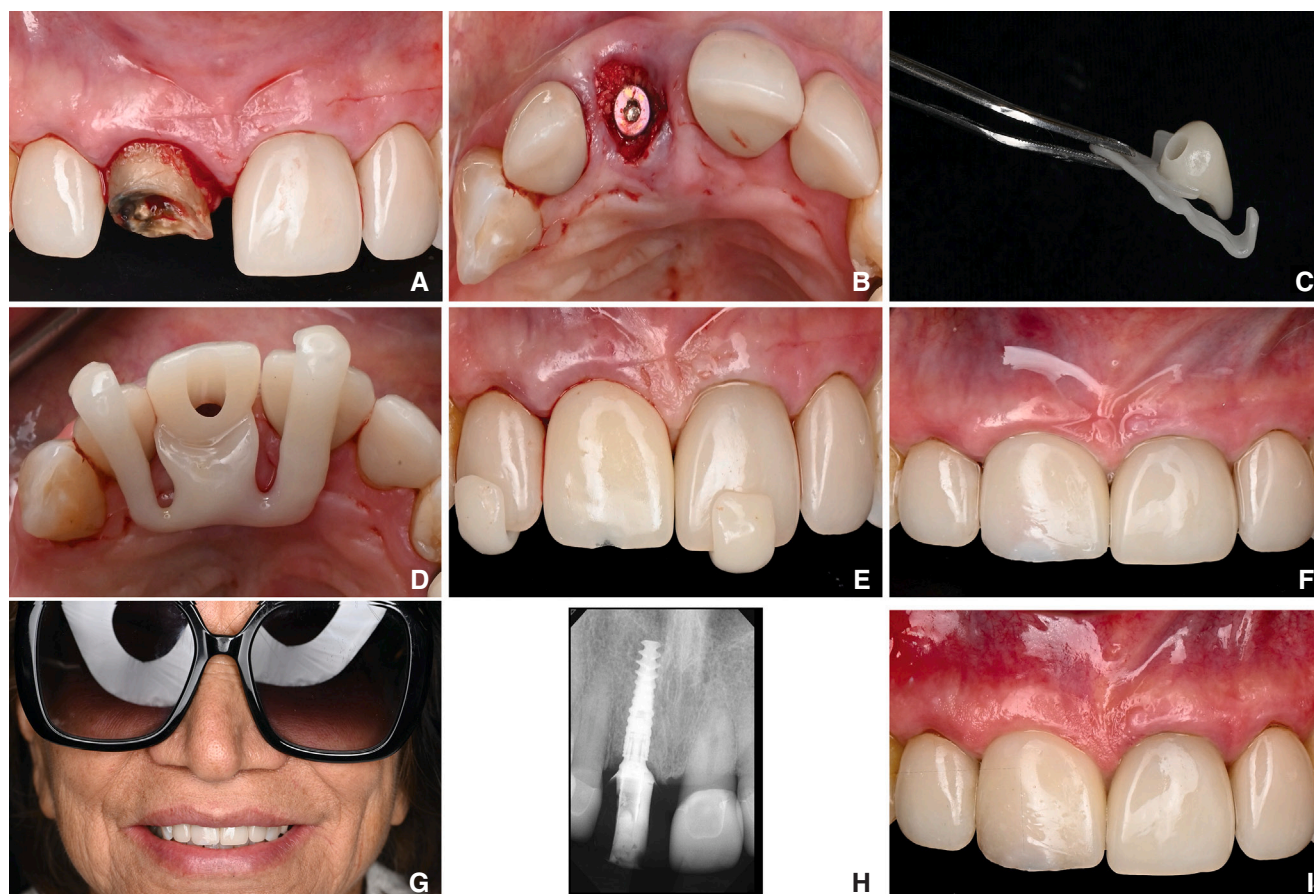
Clinical procedures. A, Extraction of remaining root of maxillary right central incisor. B, Implant placement and bone grafting of gap. C-E, Design and seating of milled immediate interim restoration. F, Frontal view of immediate implant-supported fixed screw-retained interim restoration in place. G, Extraoral view of patient's smile after placement of restoration. H, Periapical radiograph showing placed implant with seated restoration. I, Frontal view of seated interim restoration in 1-month recall visit.
